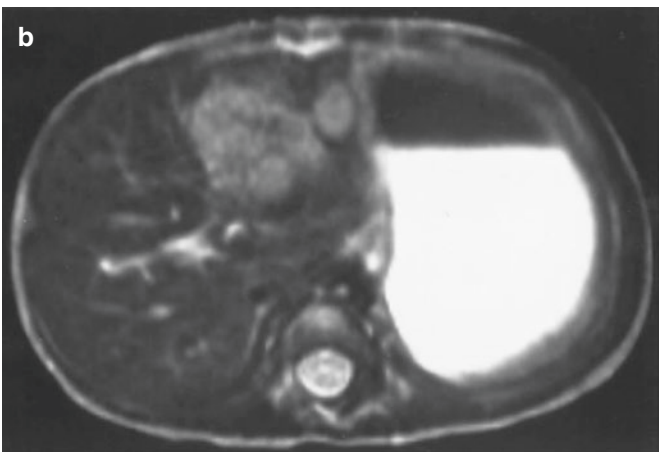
Hepatoblastoma; MRI images. MRI shows low-intensity lesion with a calcified rim (a). MRI with T2 intensification reveals a high-intensity area in S4 (b)
